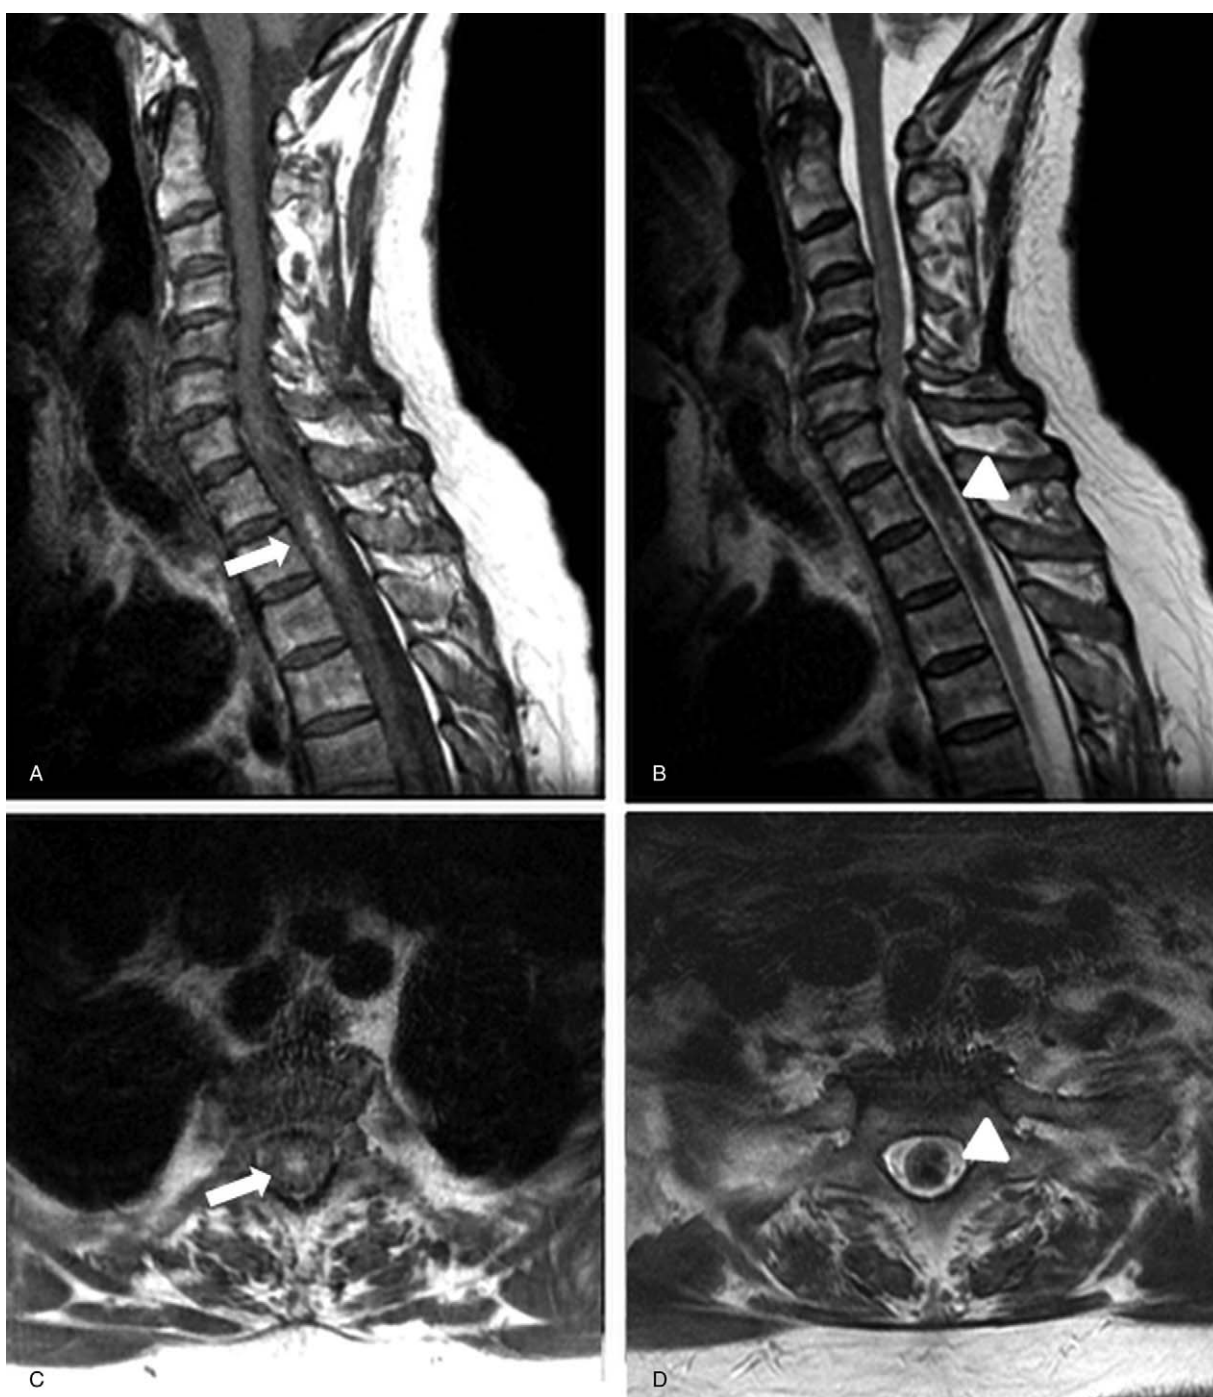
Initial MRI revealed an intramedullary spinal cord hemorrhage from C7-T3 level. T1 weighted sagittal image (A) and T1 weighted axial image (C) show high signal intensity (white arrows). T2 weighted sagittal image (B) and T2 weighted axial image (D) show low signal intensity and dark hemosiderin ring surrounding the hemorrhage (white arrowheads). MRI=magnetic resonance imaging.
